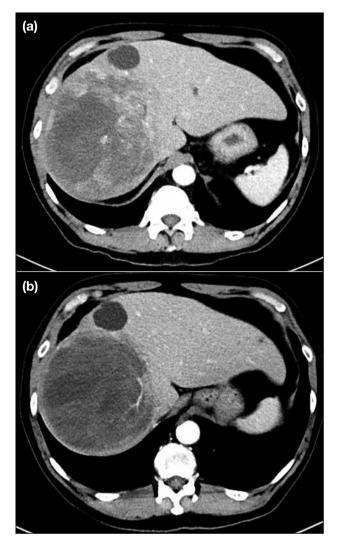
Computed tomography images of pre-⁹⁰Yttrium selective internal radiation therapy (⁹⁰Y SIRT) [a] and post-⁹⁰Y SIRT (b) in a 67-year-old patient. The known right lobe tumour showed mild reduction in size with no abnormal arterial enhancement. It suggested complete response according to modified Response Evaluation Criteria in Solid Tumors guideline.
